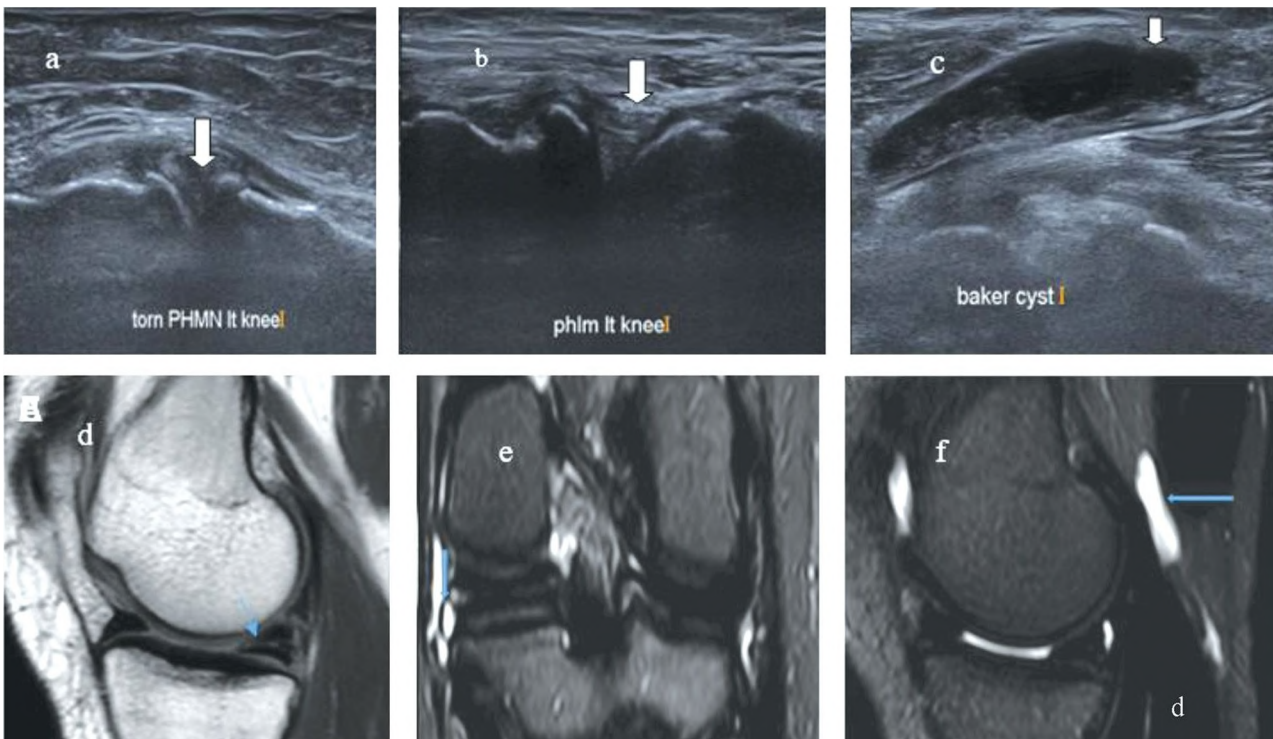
50 year old male patient with chronic knee pain; Grey scale ultrasonographic pictures of the knee joint showing PHMM tear reaching its menisco-capsular attachment (a), Intact PHLM (b), Baker's cyst with debris inside (c), Sagittal PD showed a linear intrasubstance tear of high SI of the PHMN reaching up to its root. (arrowed) (B) coronal T2 STIR showed the torn PHMN with a meniscal cyst (arrowed) (C) sagittal PD with fat suppression showed a small baker cyst (arrowed).
